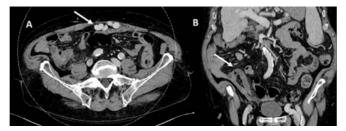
Abdominal CT intravenous contrast agent, venous phase.
